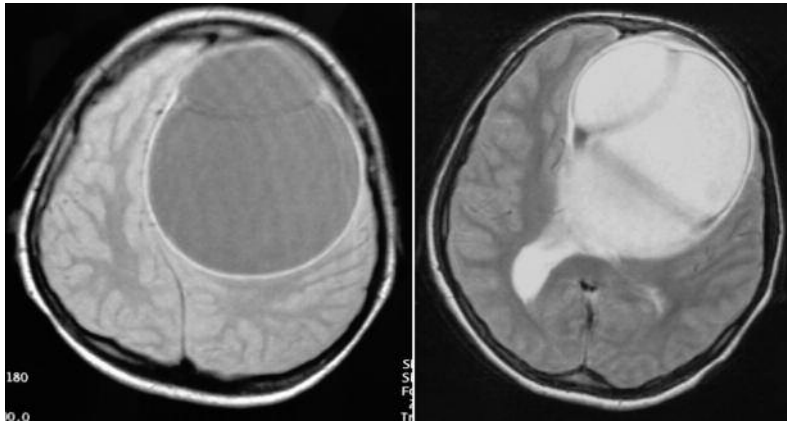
Primary multiple unifocal hydatid cyst, in which there are multiple cysts close together in MRI of the brain, shows hypo intense, well-defined, smooth edged lesion in T1W, becoming hyper intense in T2W with pressure effect on the ventricles but no hydrocephalus and surrounding edema.
